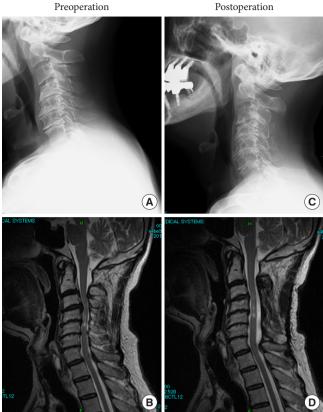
Case presentation of a 66-year-old man. (A) The preoperative C2–7 angle was -2.5° in an x-ray image. (B) Sagittal T2-weighted magnetic resonance imaging revealed cervical canal stenosis at multiple intervertebral levels with intramedullary high signal intensity. (C) After laminoplasty, the C2–7 angles improved to a lordotic angle of 22.8°. (D) Appropriate spinal cord decompression was observed postoperatively.
